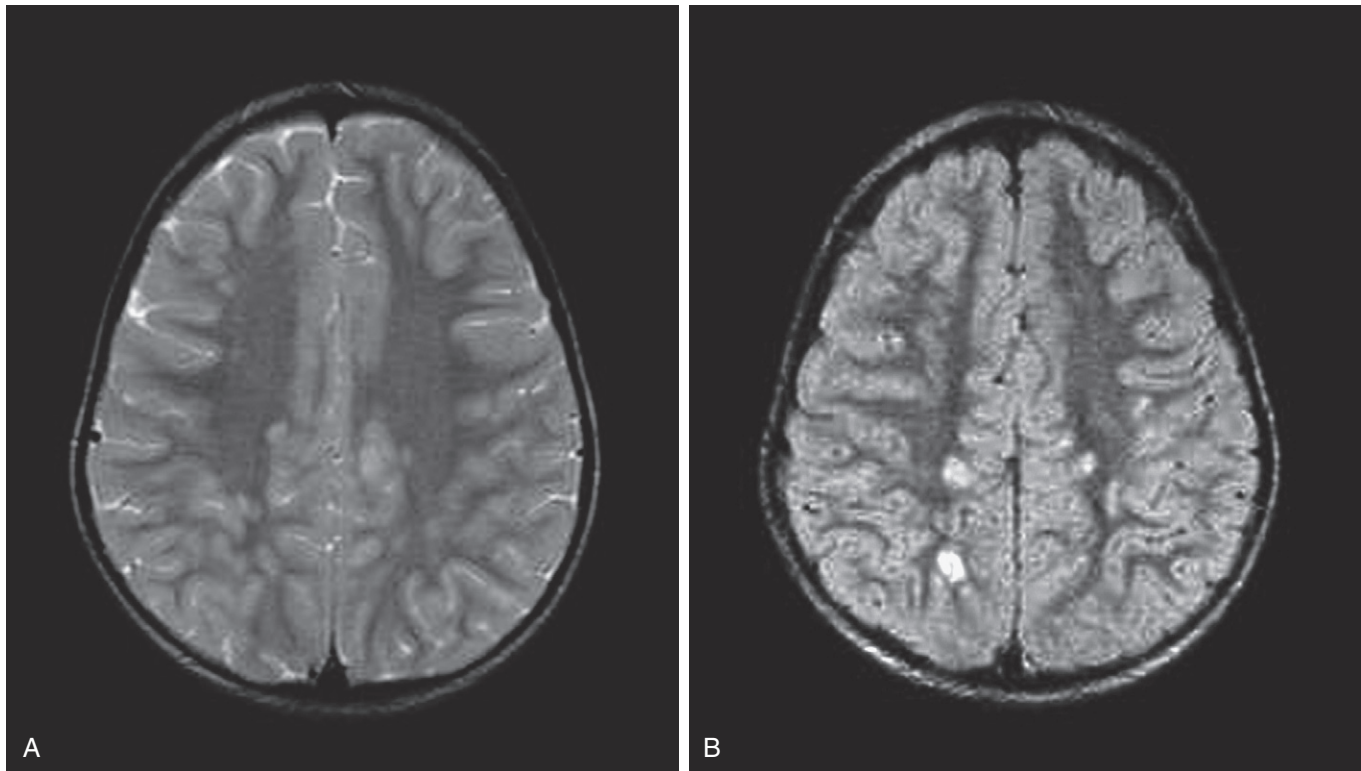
ADEM. T2-weighted (A) and FLAIR (B) images show multiple foci of hyperintensity. In addition to ADEM, vasculitis and multiple emboli could have this imaging appearance.
